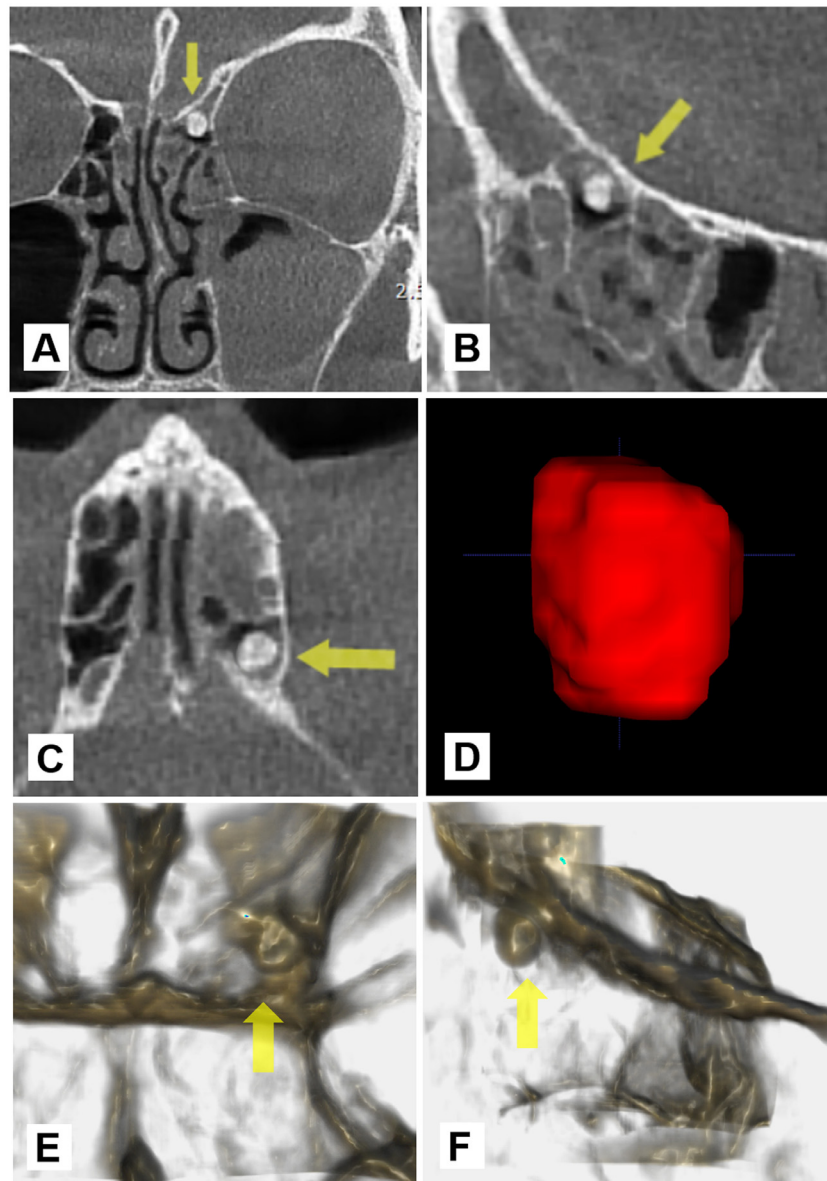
The calcified entity which located within the suprabullar cell in the left ethmoid sinus. The (A) coronal, (B) sagittal, and (C) axial view of the lesion on CBCT images also consistently showed opacities and mucosal thickening in the surrounding ethmoid cells. (D) The 3D segmentation of the lesion for volume measurement using ITK-SNAP and the clipped 3D reconstruction of the CBCT images around the calcification in (E) anterior and (F) lateral views.
